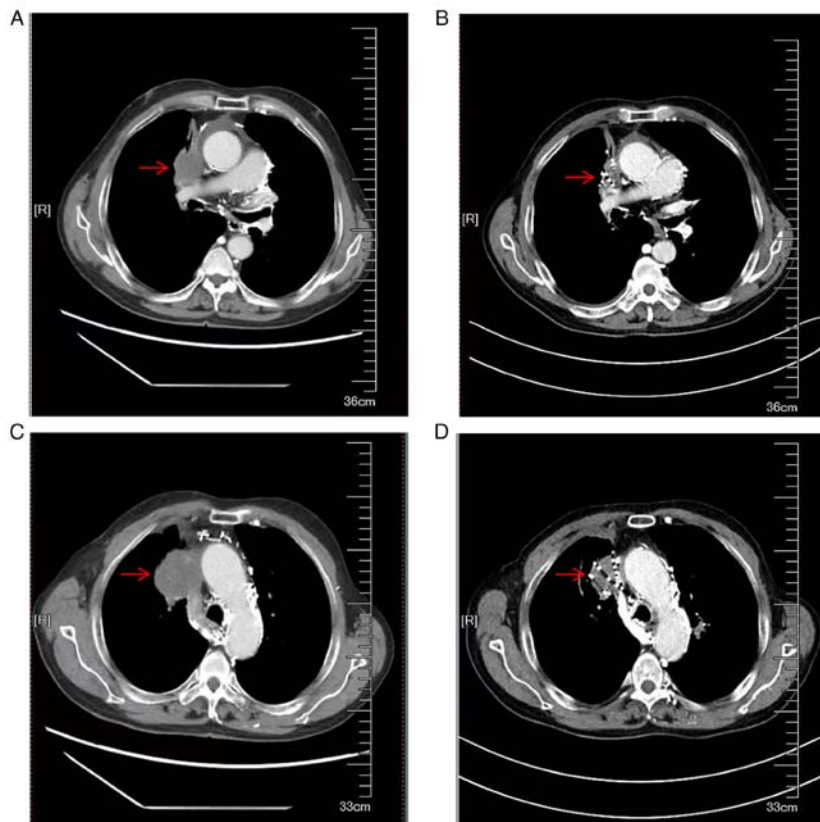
Comparison of CT images before surgery and 2 months after surgery. (A) is enhanced chest CT images of the patient's progress after comprehensive treatment; (B) is CT images of different layers of the tumor; (C) is the CT image of the same level 2 months after the implantation of particle (A and D) is the CT image of the same level 2 months after the operation of (B). Visible shrinkage of the tumor (arrow).
